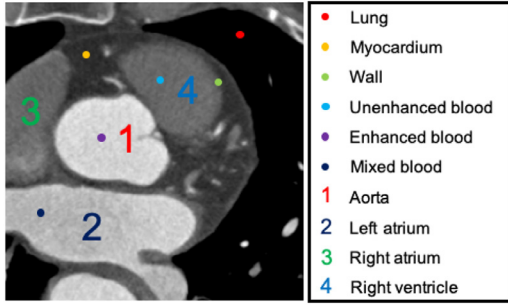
Sketch map of tissue distribution in a coronary CTA image.
